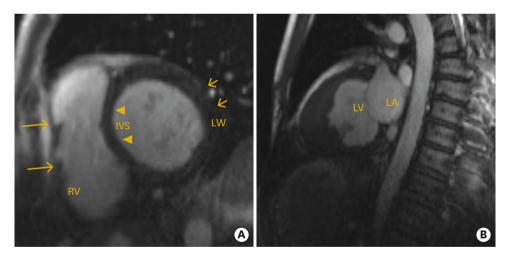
(A) Two-chamber short-axis cardiac MRI showing no involvement of the interventicular septum (arrowheads) or lateral wall of the LV (short arrows) or the free wall of the RV (long arrows). (B) Still frame from parasagittal two-chamber cardiac MRI showing no thrombus formation on the LV apex. IVS: interventricular septum, LA: left atrium, LV: left ventricle, LW: lateral wall, MRI: magnetic resonance image, RV: right ventricle.
